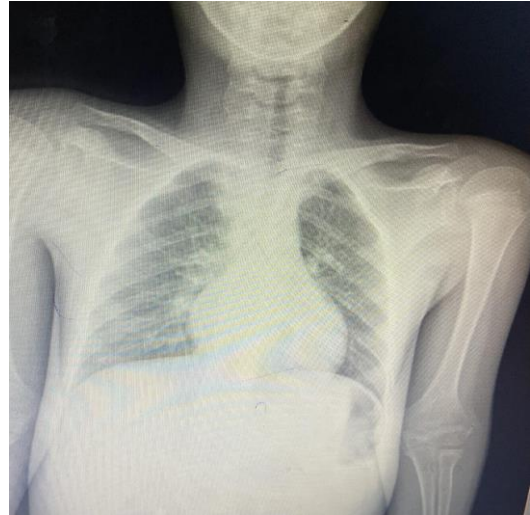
Radiographs showing normal X-ray skeleton.
